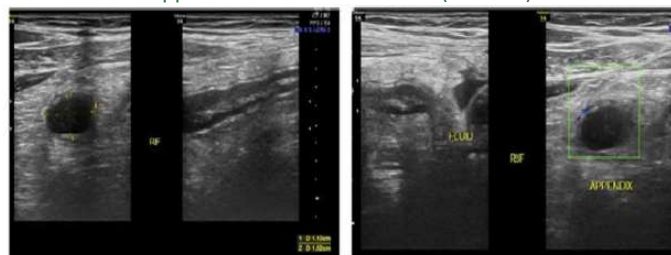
(E,F): E. Transverse & longitudinal Sonogram of the right lower quadrant in 27 years old Adult male shows a dilated, thickened non-compressible Appendix with an outer diameter of 11 mm suggestive of acute appendicitis. F. Transverse colour Doppler Image shows dilated appendix with increased flow in the wall (Grade 5).
